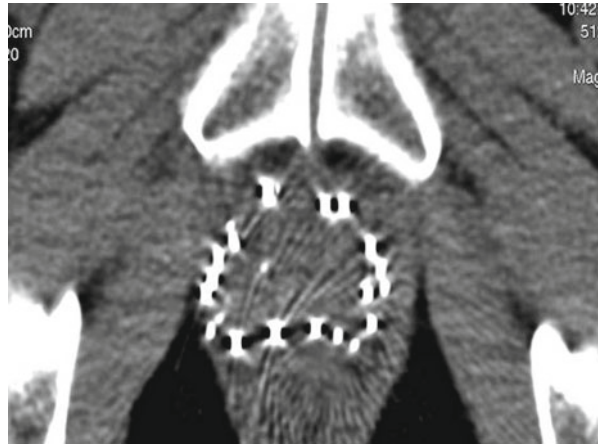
Axial CT images at prostate base (a) and apex (b) showing poor identification of prostate margins
